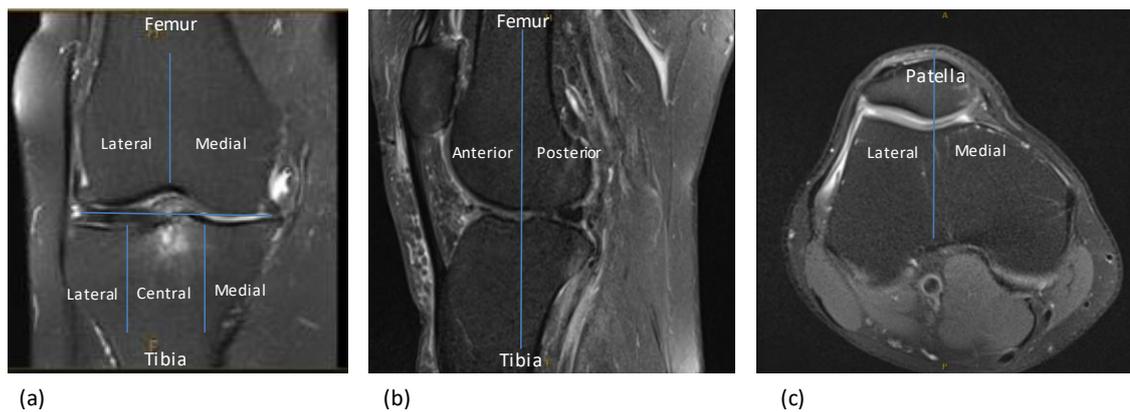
Knee joint compartments for scoring; (a) coronal, (b) sagittal, (c) axial images adopted from MRI feature analysis described by Felson et al, Kornaat et al and Peterfy et al (Felson et al., 2001; Kornaat, Ceulemans, et al., 2005; Peterfy et al., 2006).
